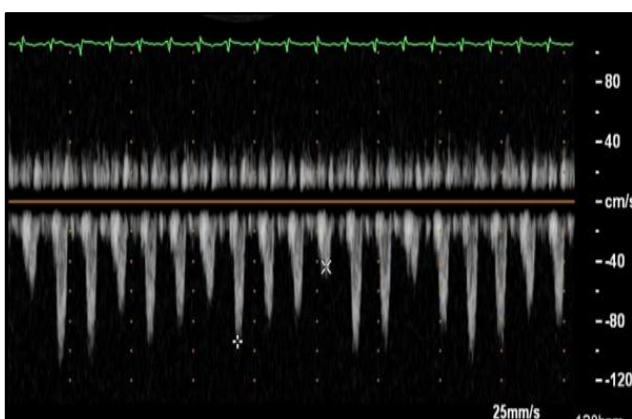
Echocardiogram-Doppler Flow Showing Exaggeration of Respiratory Variation of Mitral Flow
